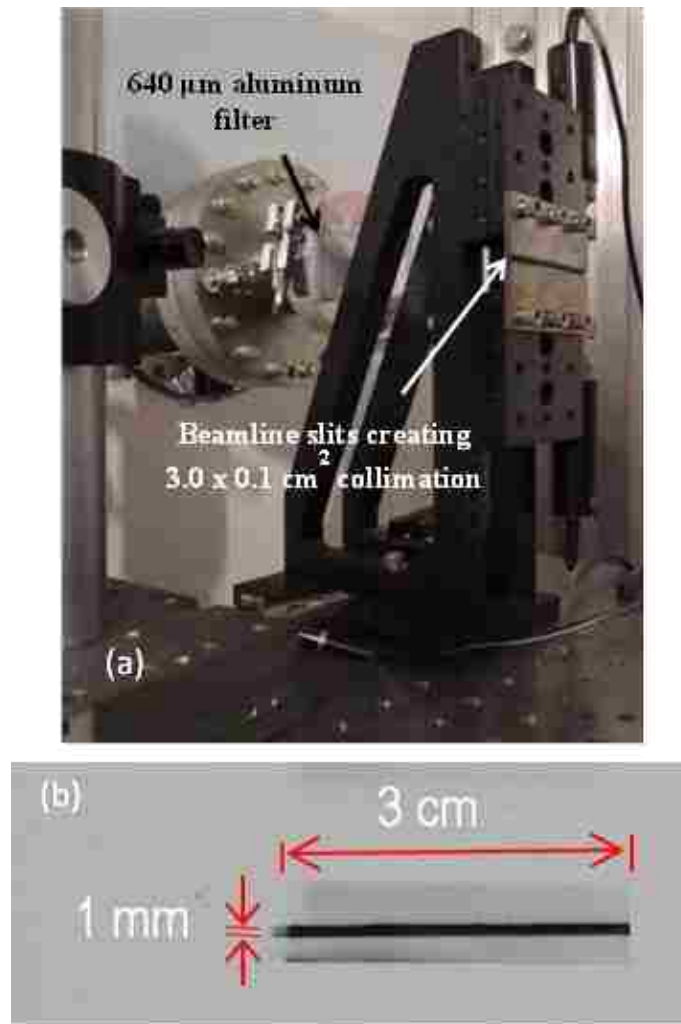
Synchrotron “strip” x-ray beam. (a) Monochromatic beam filtered by aluminum foil (640 μm thick) and collimated with tungsten beamline slits to 3.0 x 0.1 cm^2 dimensions. (b) Resulting monochromatic x-ray beam on radiochromic film (Gafchromic® EBT).
